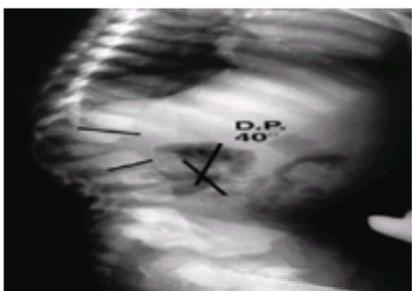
A 2-year-old child with type I congenital kyphosis measuring 40 degrees. Radiograph demonstrates failure of formation of the anterior portion of the first lumbar vertebra.
